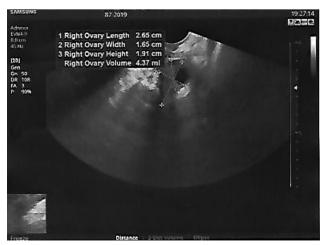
Patient 2. Transvaginal pelvic ultrasound, ovary, adhesion
